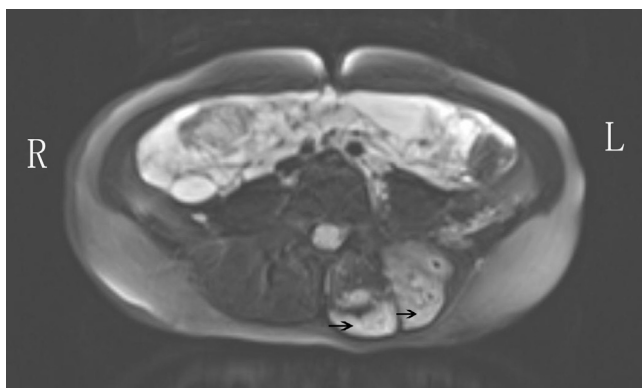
Transverse pelvic T2-weighted magnetic resonance image. Hyperintensity (*arrows*) is seen in the gluteus maximus and the fat layer, which indicated the generalized lymphatic anomaly (GLA).
